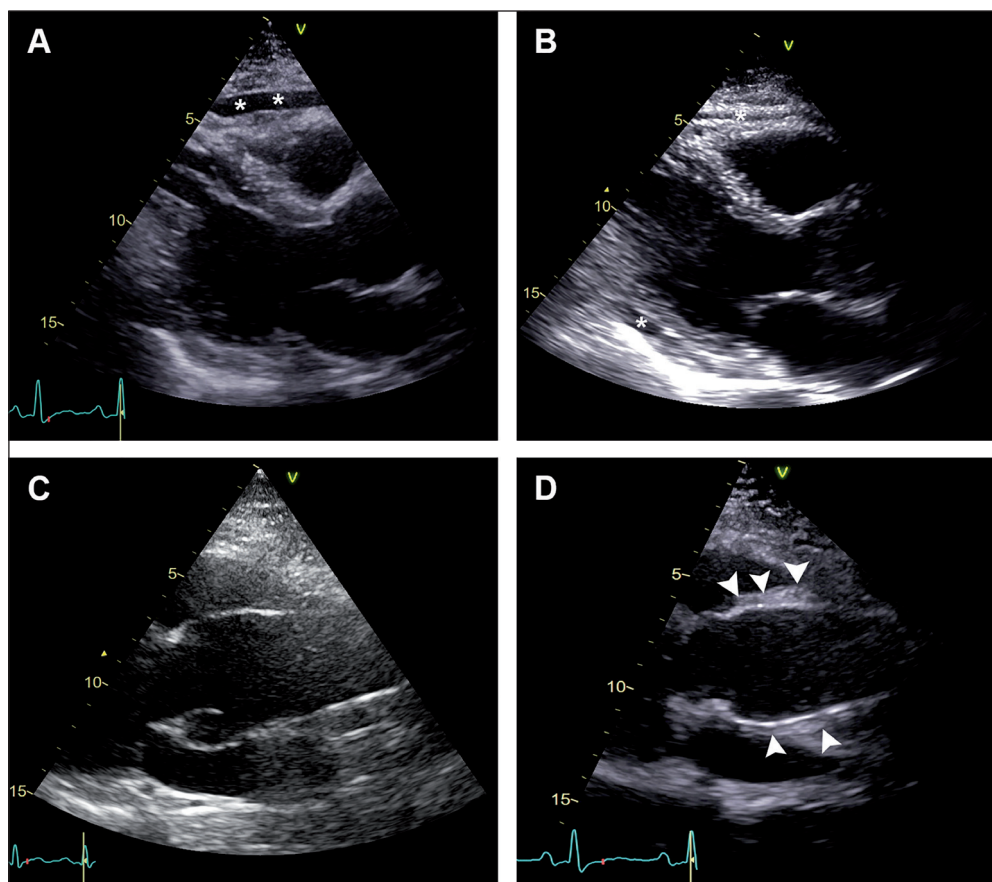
Transthoracic echocardiography demonstrating signs of inflammation after PEARs procedure. (A) Late acute pericarditis 227 days after PEARs implantation; asterisks indicate pericardial effusion. (B) Late acute pericarditis 43 days after PEARs implantation; asterisk indicates pericardial effusion. (C) Aortic root in a patient with Marfan syndrome prior to PEARs implantation (thin aortic walls). (D) Thickening of the aortic walls 6 days after PEARs implantation in the same patient as (C), having early and late recurrent fever; arrowheads indicate the inflammatory aortic wall thickening.
